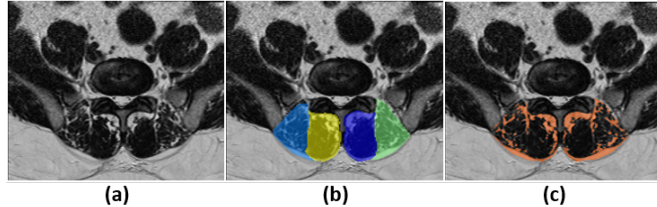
Fat separation using k-means. (a) Input T2w MRI (b) Segmentations of multifidus and spinae muscles (c) Separated fat within the muscles (in orange color).
